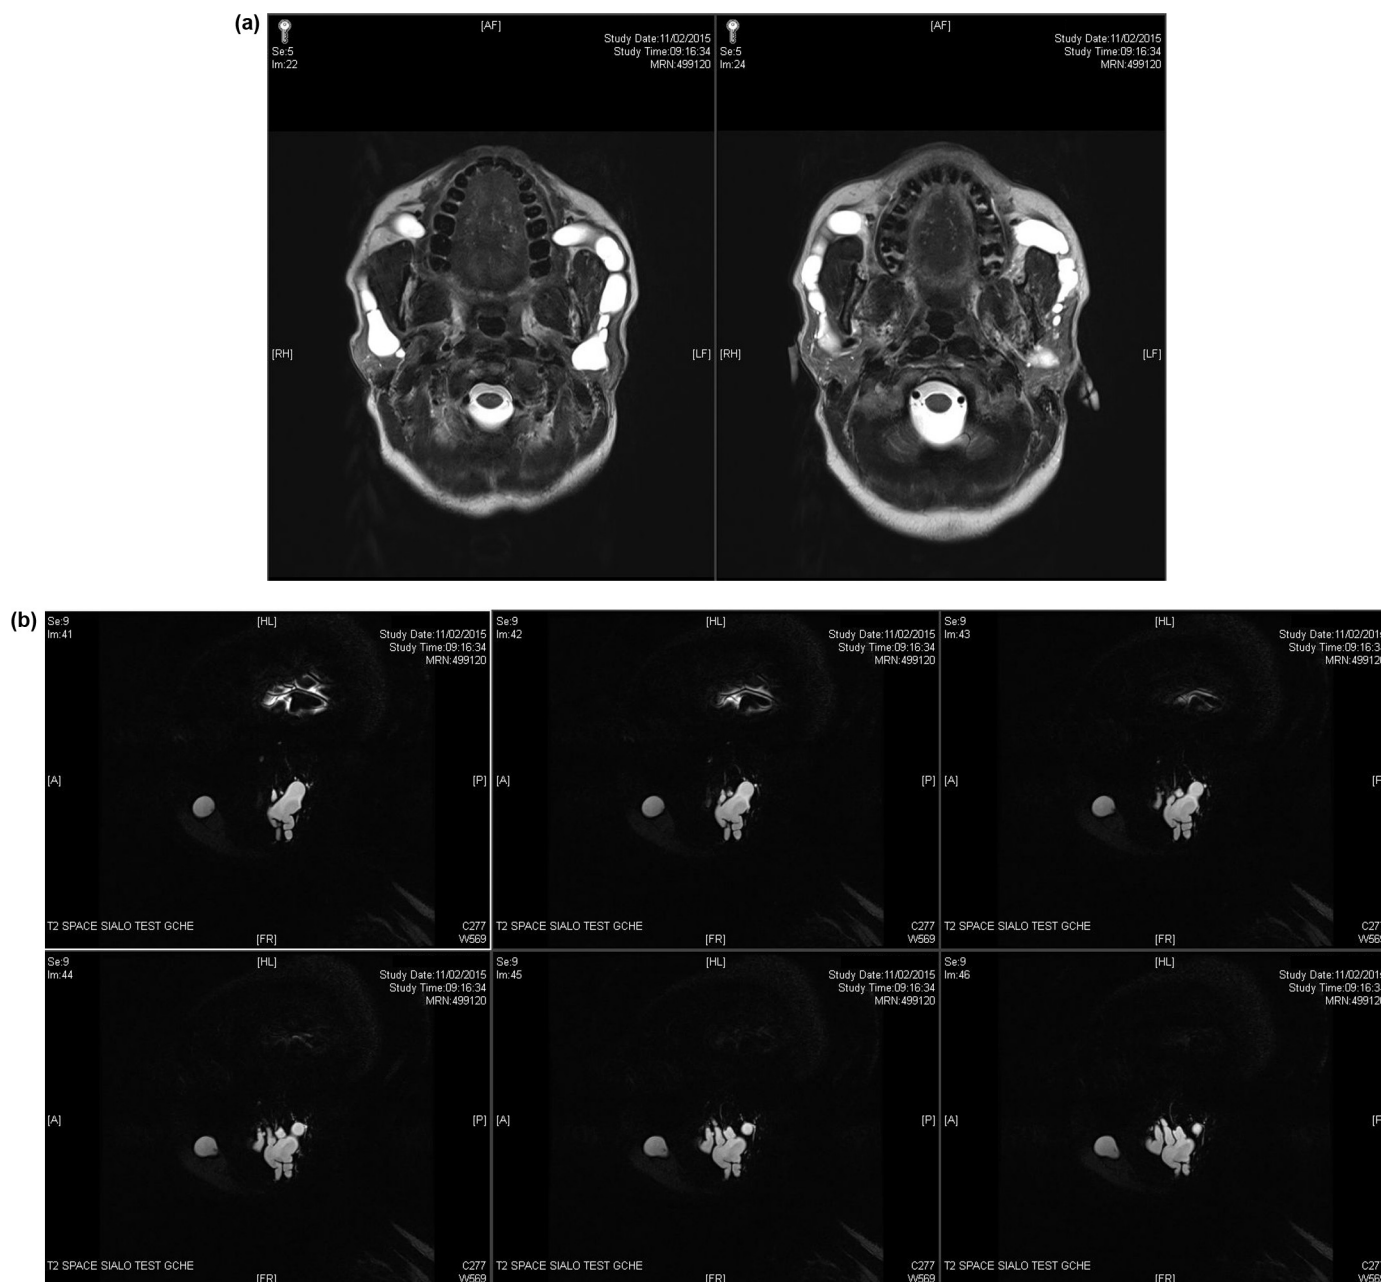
a: preoperative axial MRI slices; b: preoperative 3D Sialo-MRI: left megaduct.
